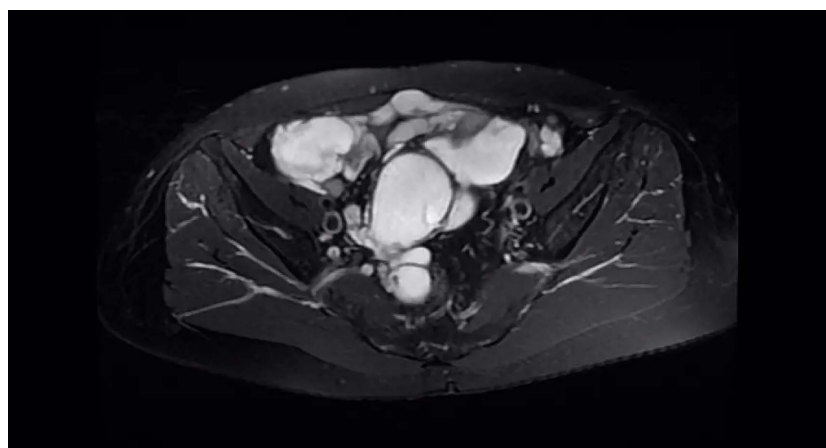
MRI Ax T2 FSE image: Small nodular and small strip-shaped low-signal shadows can be seen in the high-signal shadow.
